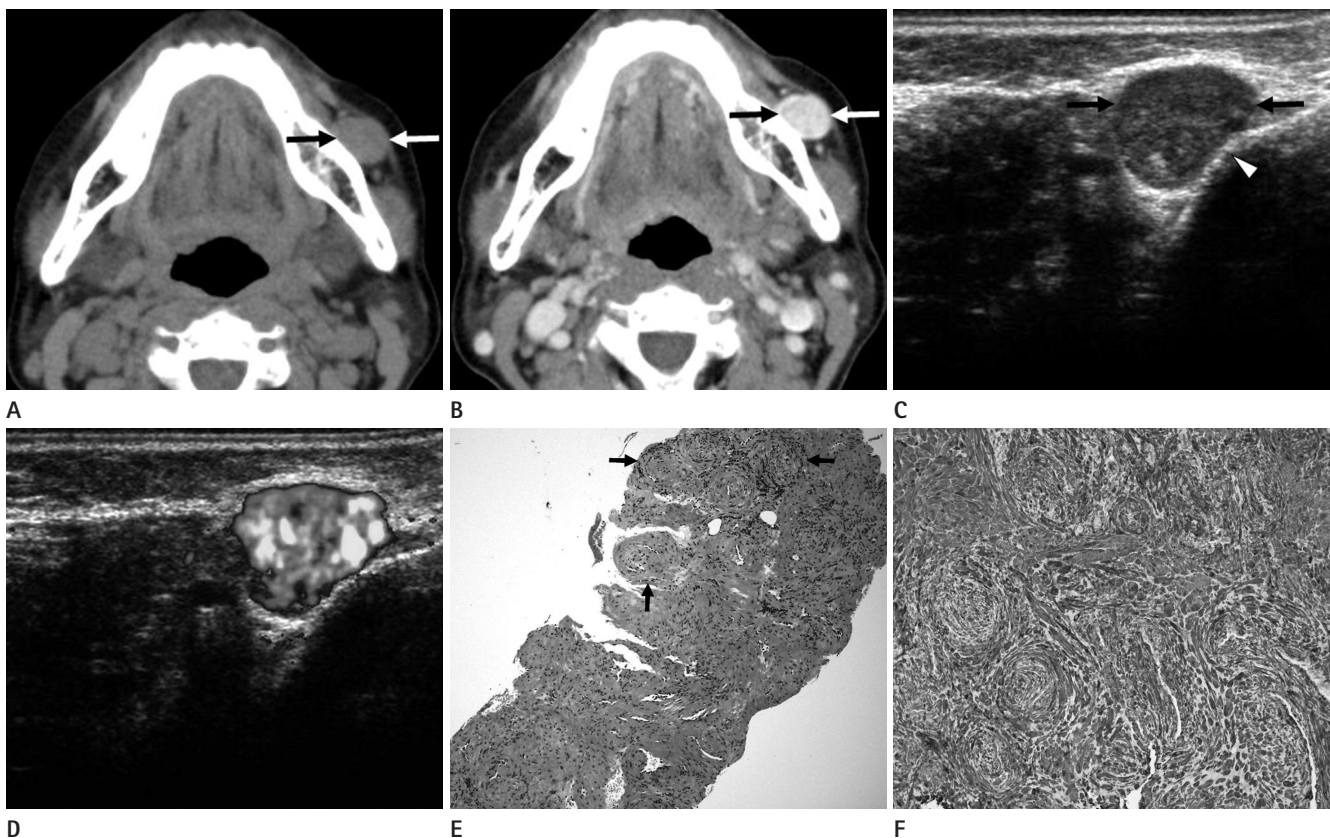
Myopericytoma of the face, diagnosed by sonographically guided core-needle biopsy (US-CNB), in a 75-year-old woman.
